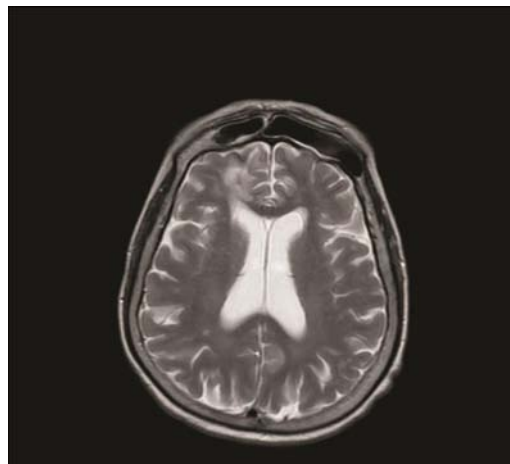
Postoperative T2-weighted axial MRI, at 32 months after surgical treatment.
